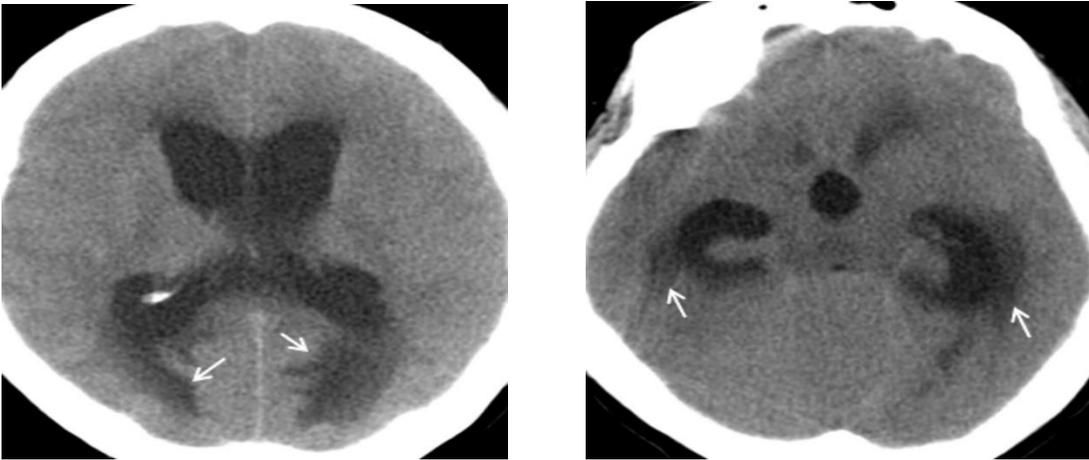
a, b) Head CT scan performed at the day of admission and showed having moderate triventricular hydrocephalus and periventricular hypodensities suggesting transependymal CSF leakage (a,b, arrows). Note the effacement of sulci, cerebral fissures and basal cisterns. The compressed brain stem is recognizable.
